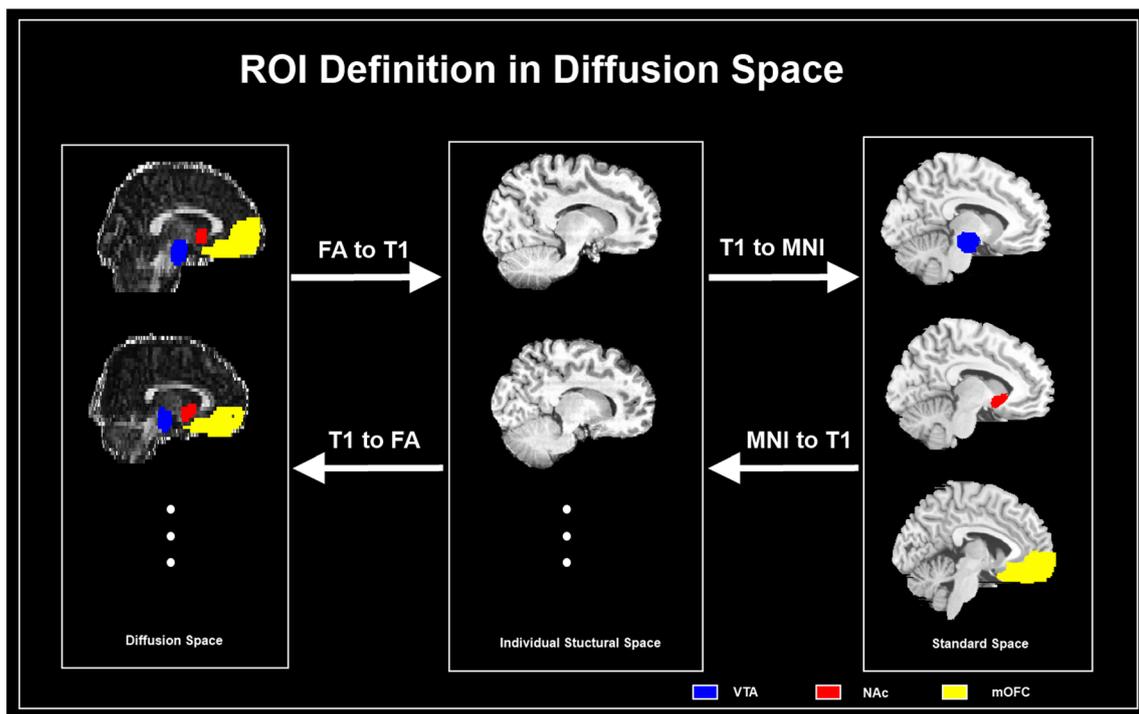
Regions of interests (ROIs) of the right hemisphere and fiber tracking analysis in diffusion space. The individual DTI image was registered to its T1-weighted structural image. The individual T1 images were
